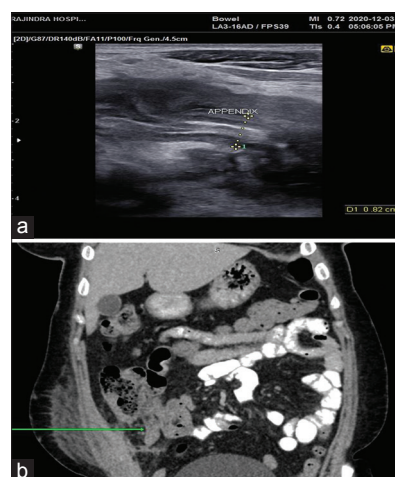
(a) Ultrasound, (b) CECT abdomen coronal section
